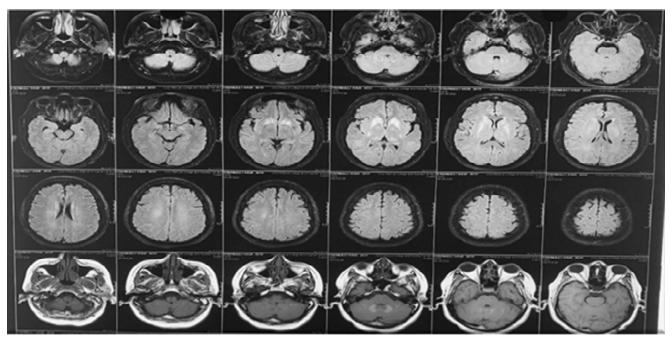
MRI brain showing hyperintensities in bilateral basal ganglia, and dentate nuclei.
